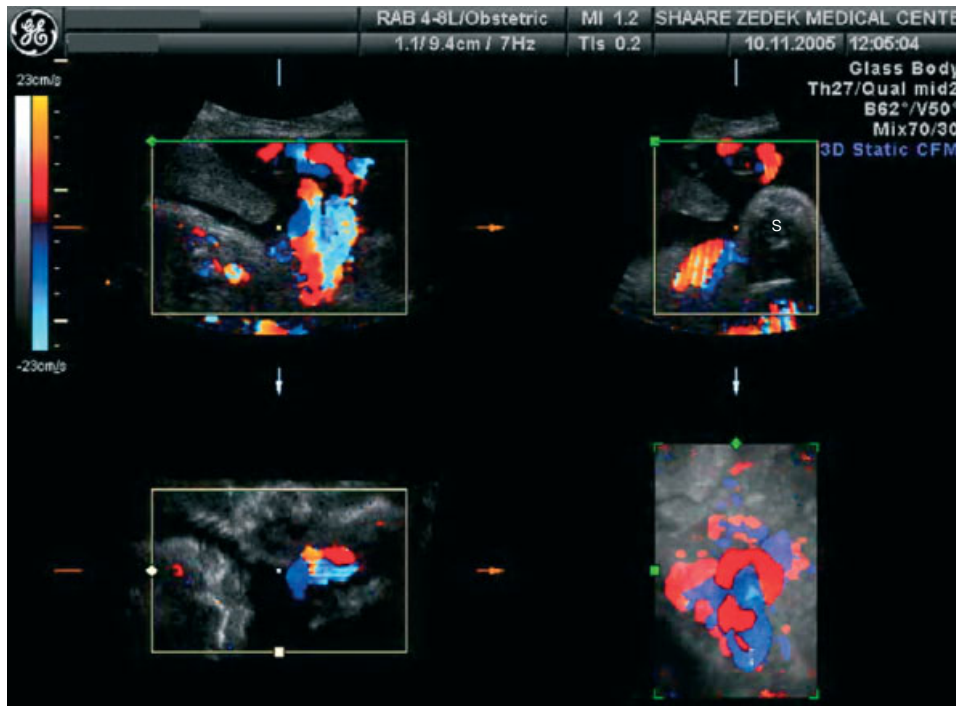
Multiplanar and three-dimensional color Doppler images of a cord loop and the fetal shoulder (S) in the herniated amniotic sac.
